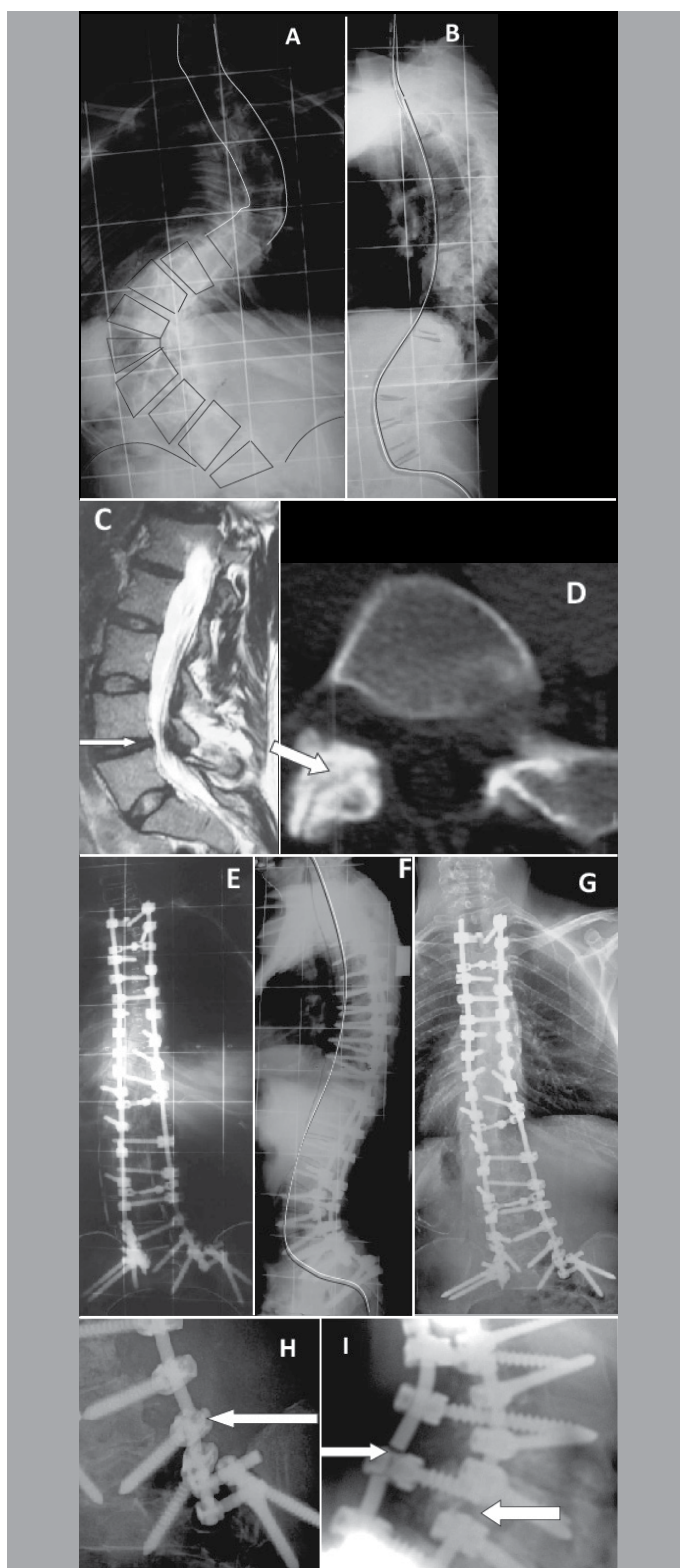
Patient, 39 years of age, diagnosed with idiopathic scoliosis, with bilateral lumbosciatica and chronic back pain for the previous five years. She walked normally. She presented left thoracolumbar scoliosis of 104° Cobb, with thoracic lordosis of -15° and kyphosis in the thoracic-lumbar transition (Figures 2A and 2B). There was L4-L5 discopathy with central canal and foraminal stenosis (Figure 2C) and severe bilateral L5-S1 facet joint arthrosis (Figure 2D). She underwent T2-iliac fusion surgery using pedicle screws and two iliac screws bilaterally. Postoperative control was correct, with the exception of a slight imbalance in the right trunk (Figures 2E and 2F). Twelve months after intervention, the patient noticed pain in the lumbosacral region and a crunching sound when making a forced movement. Radiography confirmed breakage of the two rods (Figures 2G, 2H, and 2I).
